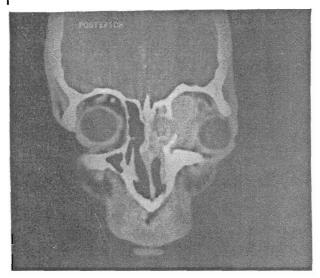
Coronal CT of paranasal sinus and orbit showing an infiltrating mass involving ethmoids and orbit with loss of tissue planes (invasive fungal sinusitis).
